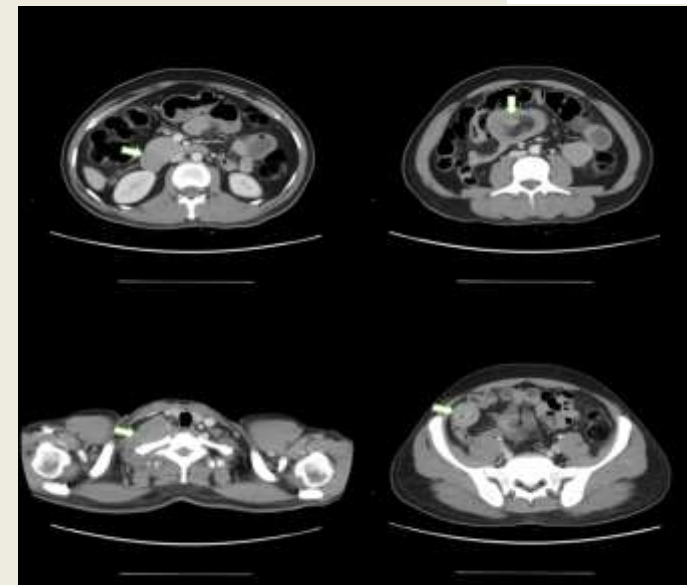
Contrast enhanced CT shows right supraclavicular mass and multiple small bowel polypoidal lesions.
